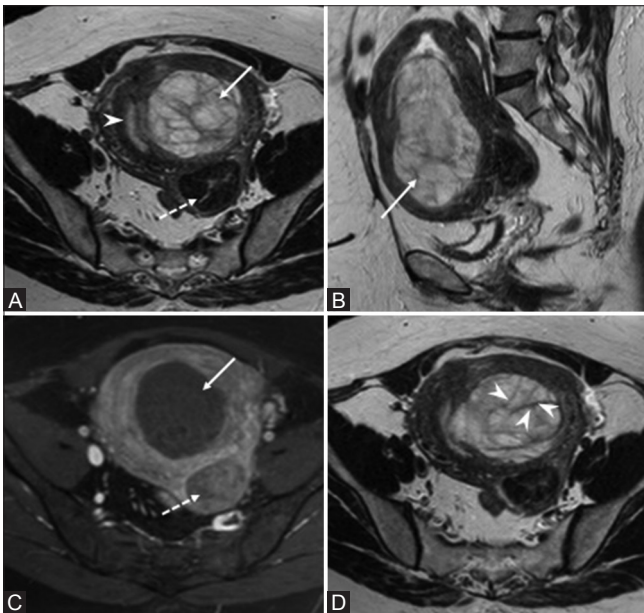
(A-D): (A and B) T2 weighted MRI in axial, sagittal sections shows a mass arising from the anterior submucosal myometrium and filling the endometrial cavity (white arrow). Arrowhead is the compressed endometrium. Dotted arrow is the posterior subserosal fibroid. (C) T1 post gadolinium contrast in axial sections depicts no enhancement of the submucosal mass (white arrow) as opposed to the fibroid posterolaterally which shows homogenous enhancement (dotted arrow). (D) T2 weighted MRI in axial section shows linear hypointense areas corresponding to split fibers (arrowheads)
